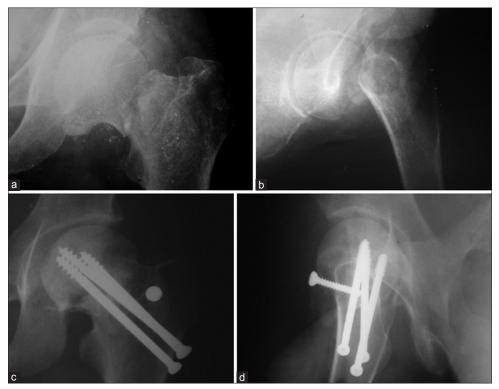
X-ray left hip joint (a) Anteroposterior view of 55 years old patients with 5 weeks old trauma showing fracture neck of femur (b) Laterial view of same patient showing old fracture neck of femur (c) Postoperative x-ray anteroposterior view after 14 weeks of followup of same patient showing implant *in situ* and union (d) Laterial view after 14 weeks of followup showing implant *in situ* and union
